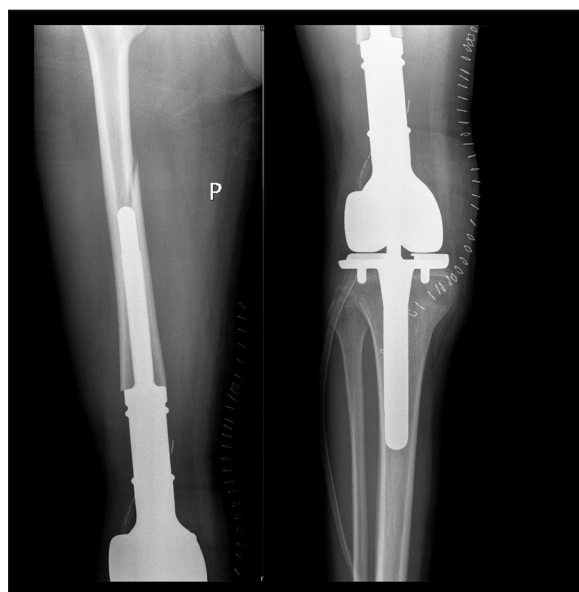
17-year-old boy with femoral osteosarcoma one year after implantation of endoprosthesis. X-ray: fracture of the femoral stump.
